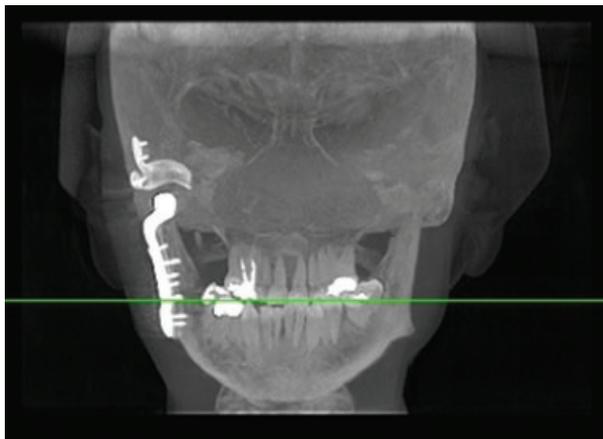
Postoperative CT scan showing patient-fitted prosthetic temporomandibular joint replacement with adequate midline dental alignment and canting reduction.
